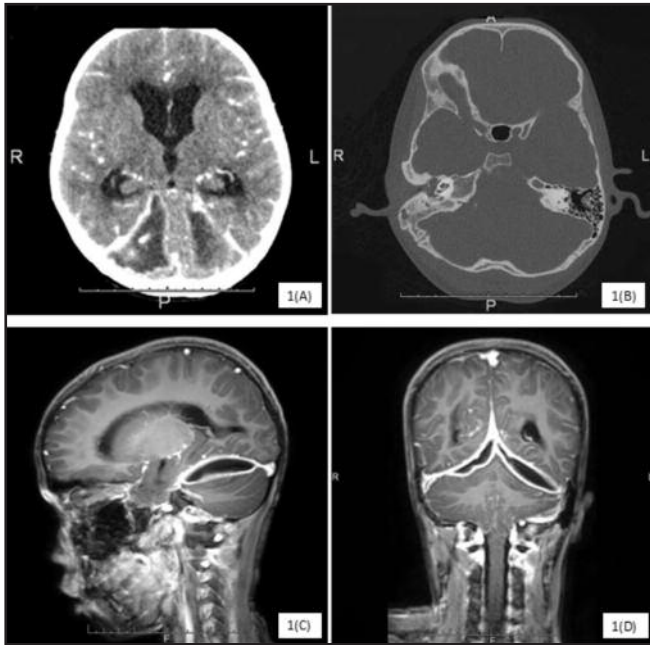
Subtentorial empyema. (A) Contrast-enhanced CT scan brain, axial view, showed bilateral multiloculated subtentorial collection with dural enhancement and obstructive hydrocephalus; (B) CT scan bone window demonstrated opacity at the right mastoid air cells which suggestive of mastoiditis. MRI brain was then performed additionally to delineate more clearly the extent of the intracranial infective collection. (C) MRI brain sagittal view & (D) MRI brain coronal view.
